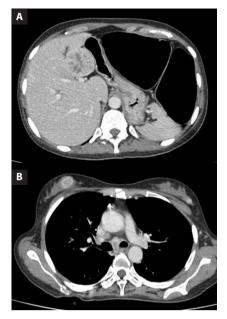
Axial CT image show a representative metastatic liver lesion; B. Axial CT image show enhancing bilateral breast nodules and interval progression in mediastinal nodes (previous CT not shown);
